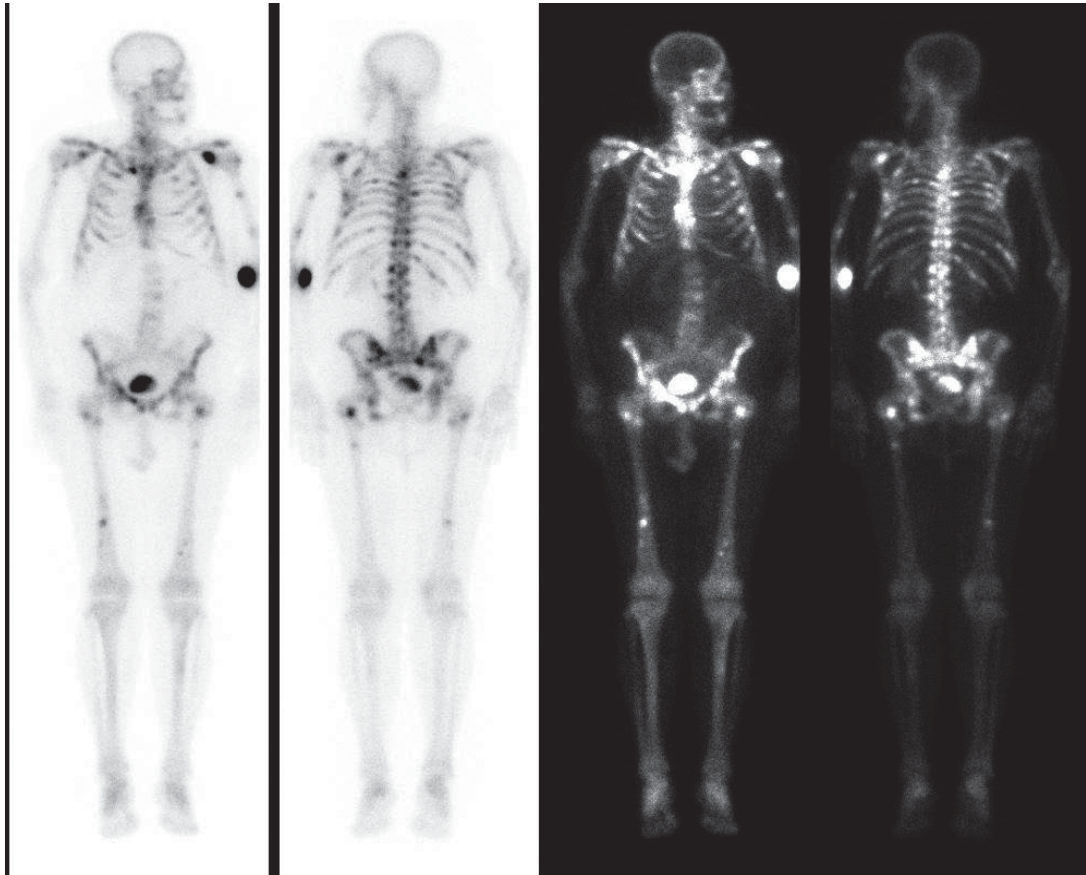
Bone scintigraphy. Anteroposterior and posteroanterior views in different gray-scales. Bone metastasis in patient with advanced carcinoma of the prostate. Multiple bone metastases prevalently in the vertebral column and pelvis documented by increased radiotracer uptake
